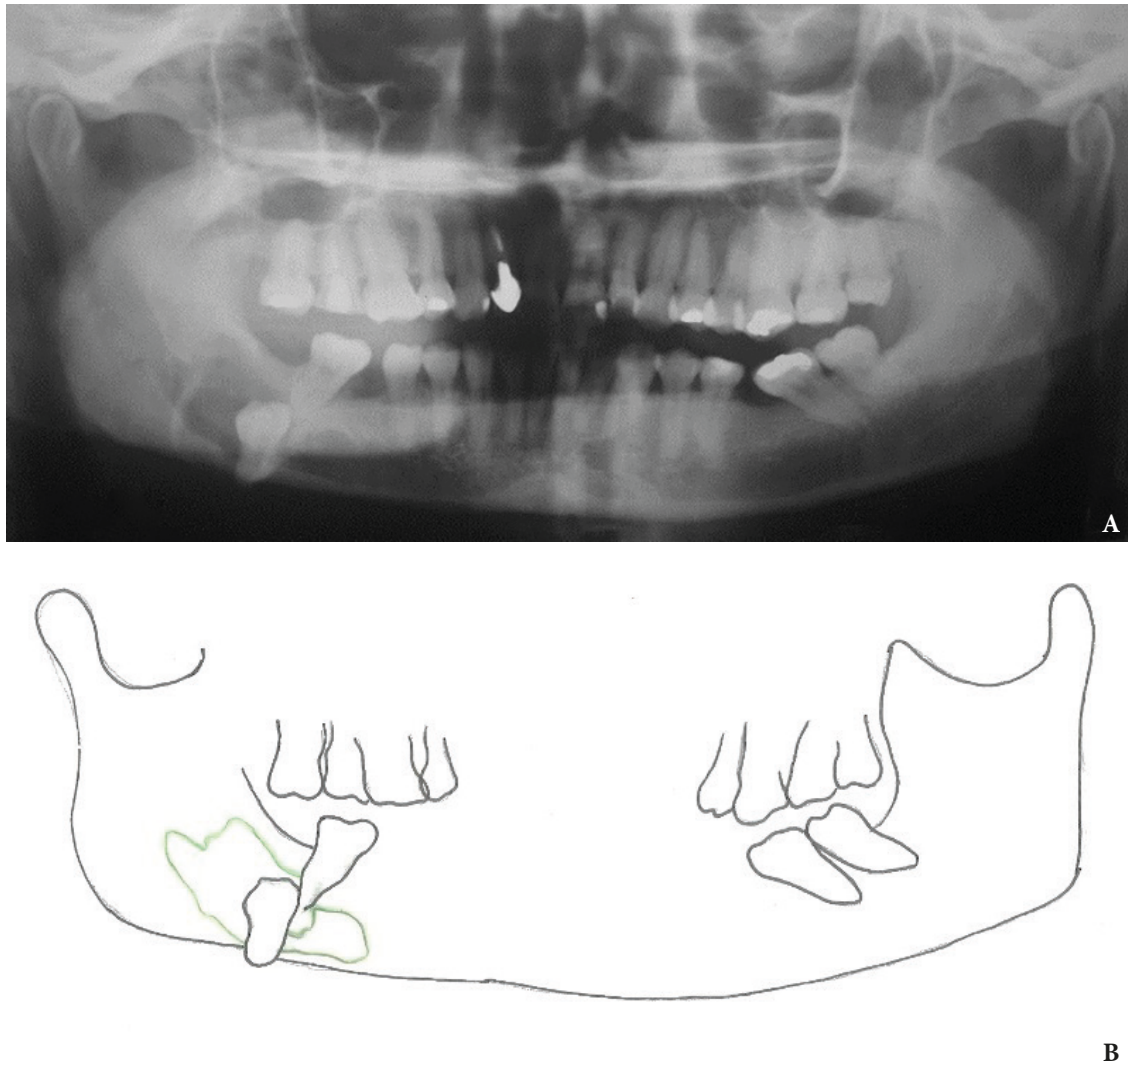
Case 5. A: Initial X-ray. B: Lesion size scheme (*green*) for resection.
